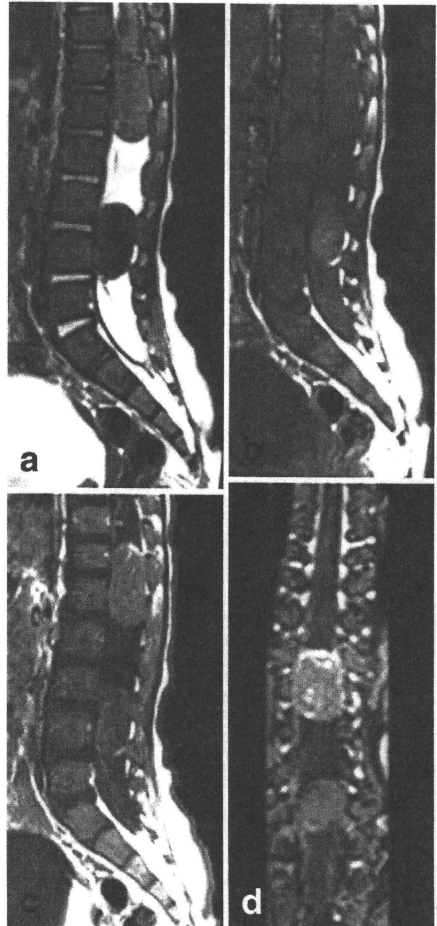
Magnetic resonance imaging (MRI) revealed well-circumscribed masses at the T12-L1 and the L3-L4 level. The rostral mass was hypointense on both T₂-weighted (a) and T₁-weighted (b) images with homogeneous enhancement (c, d). The caudal mass was hypointense on T₂-weighted (a) and slightly hyperintense on T₁-weighted (b) images with faint enhancement (c, d).
